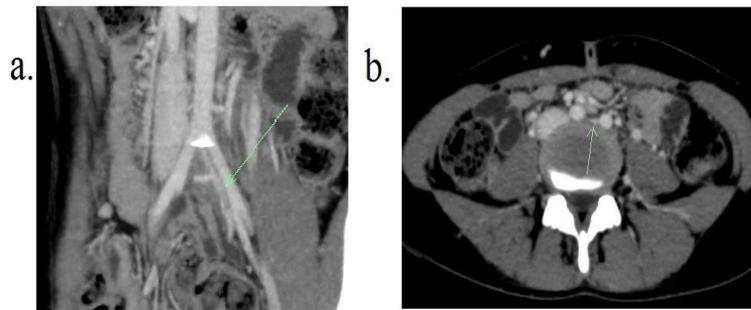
Coronal and axial contrast CT showing compressed and stenosed left common iliac vein (arrow) due to overlying right common iliac artery.
